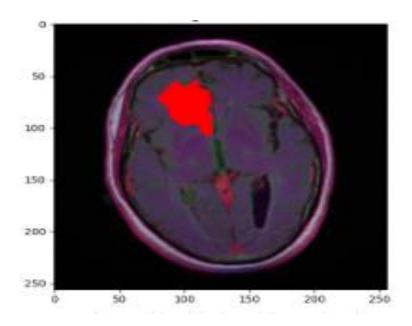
Brain MRI with original mask
